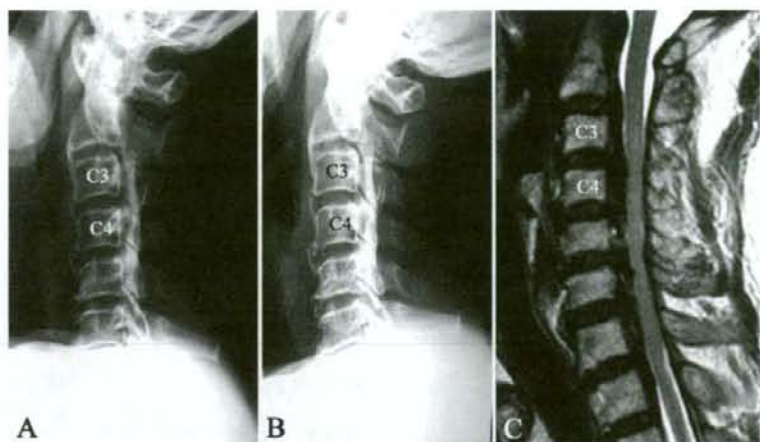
Case 1. Flexion (A) and extension (B) cervical radiographs obtained at presentation in a patient with mixed-type OPLL. The residual space available for the cord is 7 mm at C3-4, and the C1-7 ROM is 23°. Anterior impingement of the spinal cord at several levels is visible on a T2-weighted, midsagittal MR image (C), but no HSCs are visible.
